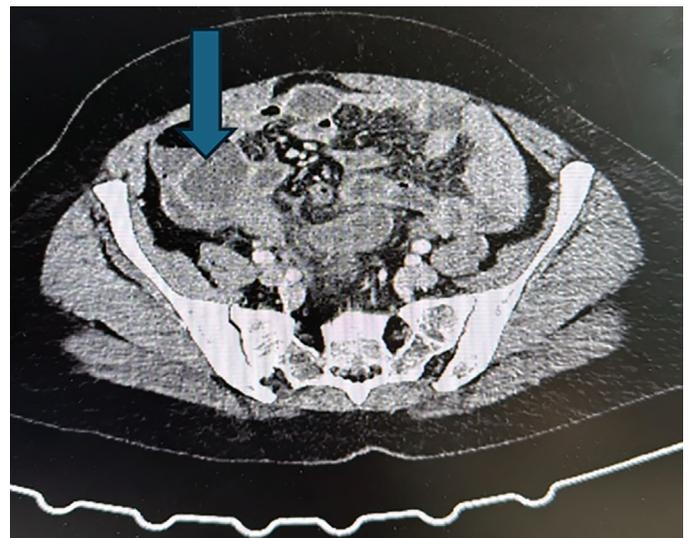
CT image demonstrating the appendix and surrounding tissues (900×512)
